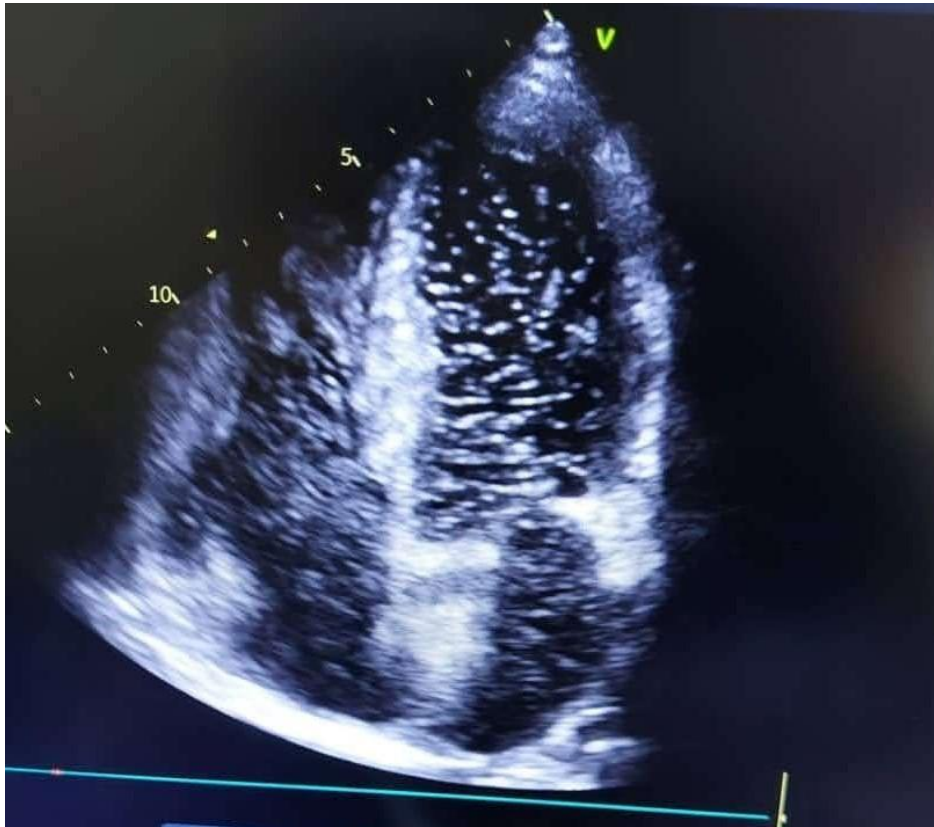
Contrast Echocardiography with agitated saline showed bubble appearance in left atrium and left ventricle after 3rd cardiac cycle suggestive of right to left intrapulmonary shunting
